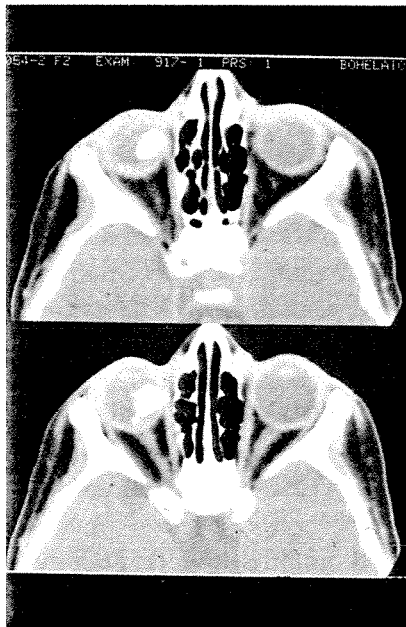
(Nasr) CT-scan. Intraocular retinoblastoma with marked calcification.
